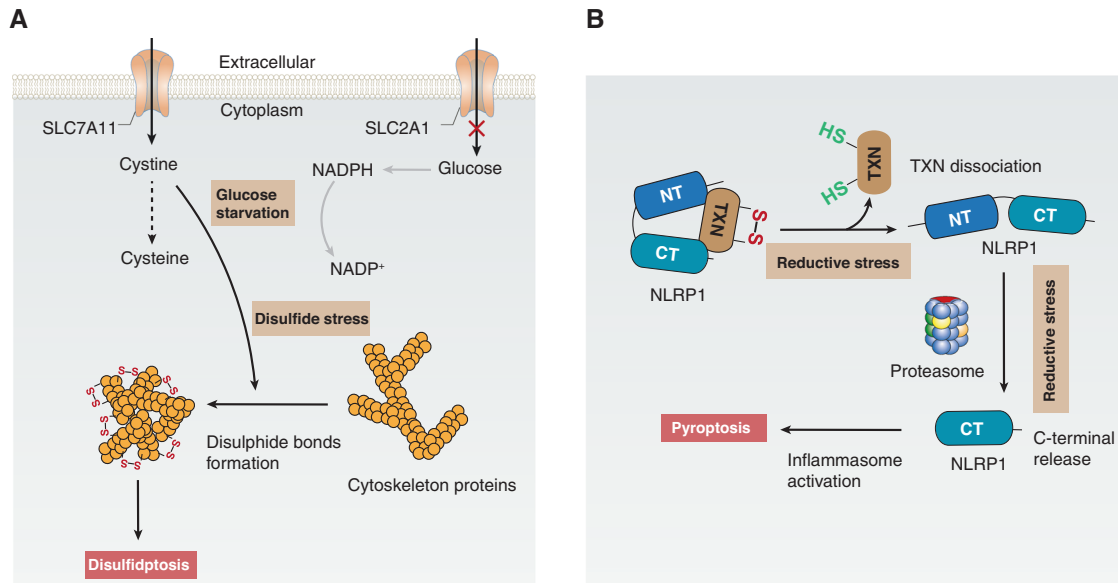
Signaling and mechanism of reductive cell death. A Glucose starvation leads to NADPH depletion and the accumulation of intracellular disulfide and cysteine, thereby increasing disulfide stress in SLC7A11-overexpressing cancer cells. Disulfide stress further induces excessive disulfide bonds formation in actin cytoskeletal proteins, resulting in disulfidptosis. B On the one hand, reductive stress eliminates the oxidized form of TXN in the NLRP1 protein complex and removes TXN; on the other hand, reductive stress accelerates proteasome-mediated degradation of the repressive NT fragments of NLRP1 and releases the inflammasome-forming CT fragments from autoinhibition, thereby promoting inflammasome activation and subsequent pyroptosis in immune cells.
